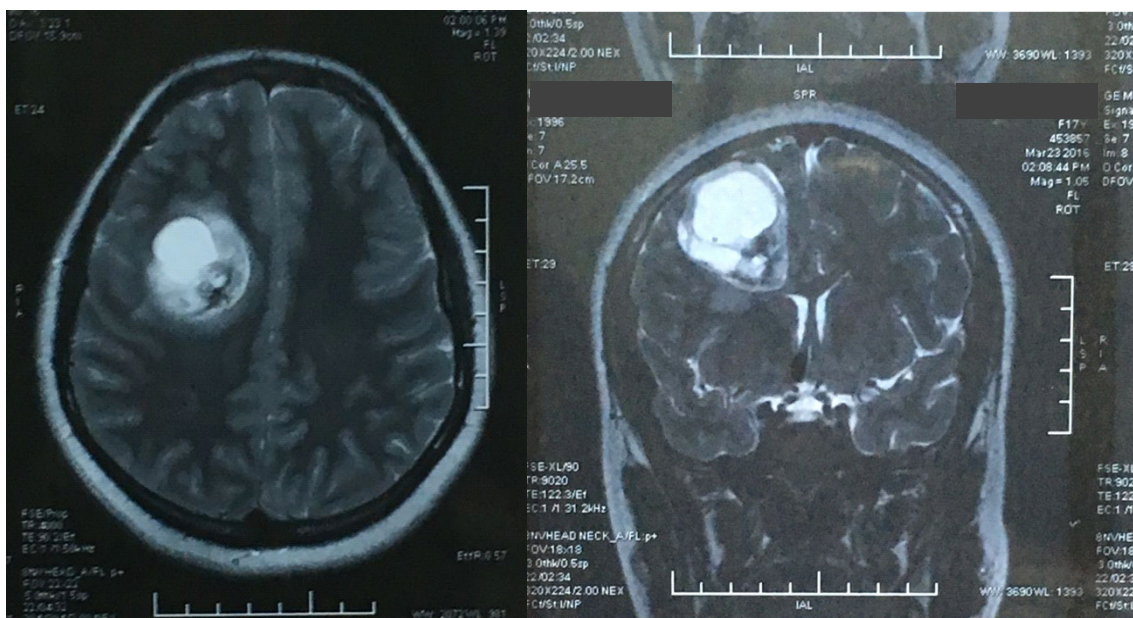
& 2): MRI, pseudo cystic mass seen in the right temporal part of the cerebrum. No peritumoral edema present.
